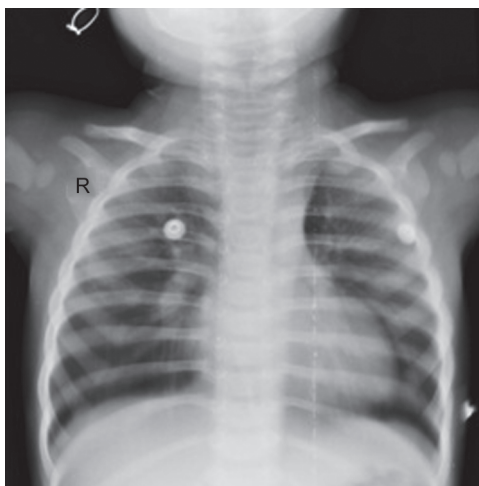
Chest/neck radiograph showing steeple sign
